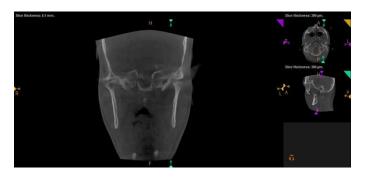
Sagittal section of CBCT showing reduction in the dimensions of the right and left condyles
